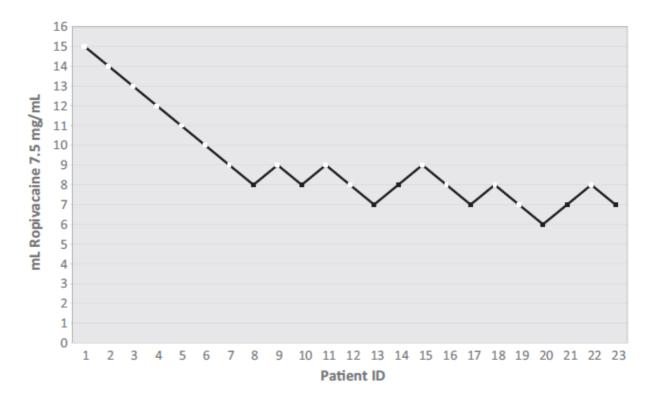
Up-and-down sequence of the ultrasound-guided block of the posterior and lateral cords of the infraclavicular brachial plexus using ropivacaine 7.5 mg/ml.
